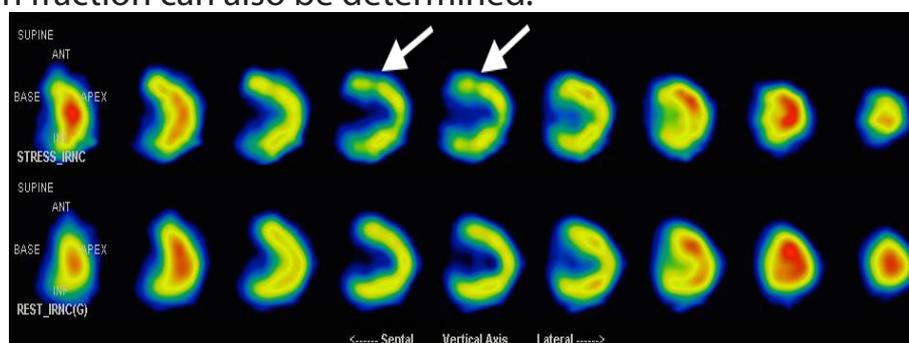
Myocardial perfusion using gated SPECT at rest and after adenosine stress. Resting images are depicted in the lower row. Stress images are depicted in the upper row. Reversible perfusion defects were observed in the antero-septal regions (arrows). *Courtesy of Dr Maria João Cunha.*
